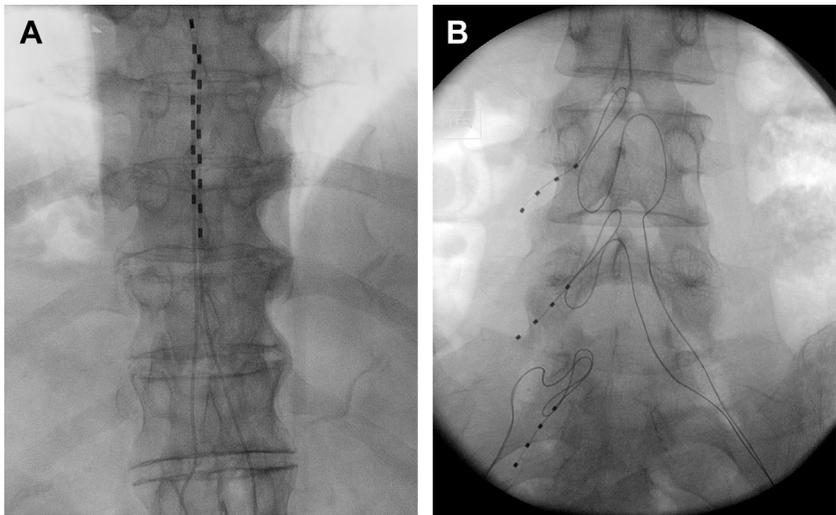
(A) Radiograph of 2 epidural spinal cord stimulator leads. (B) Radiograph of 3 DRG stimulator leads placed at L4 (fourth lumbar level), L5, and S1 on the left side.
